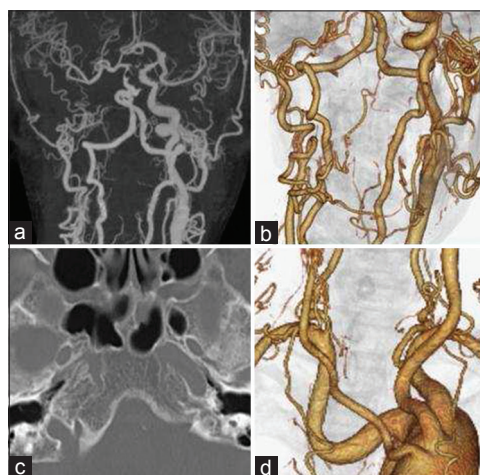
(a) Maximum intensity projections of computed tomography (CT) angiography demonstrate stenosis of the basilar artery and aplasia of the right common carotid artery. (b) Multiplanar reconstruction of CT angiography of the neck demonstrates aplasia of the right internal carotid artery. (c) Skull base CT scanning demonstrates an absence of the right carotid canal. (d) Abnormal origin and course of the left subclavian vessels are demonstrated. Bilateral common carotid arteries have arisen from the distal side of the left subclavian artery.
